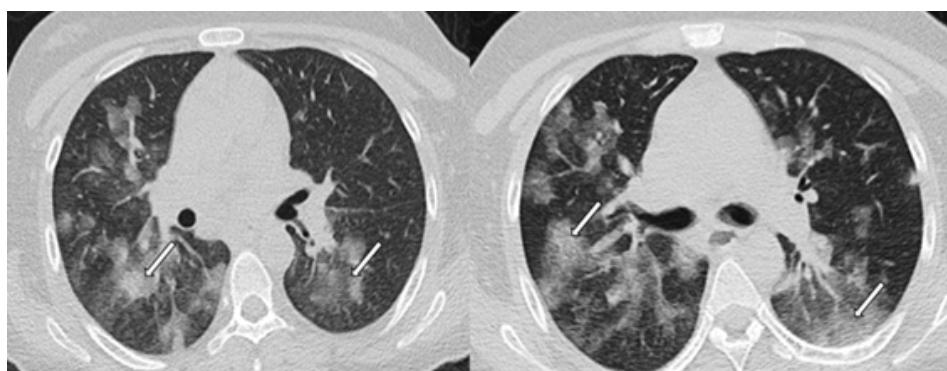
Chest CT shows bilateral round ground-glass opacities and bilateral patchy consolidations.
